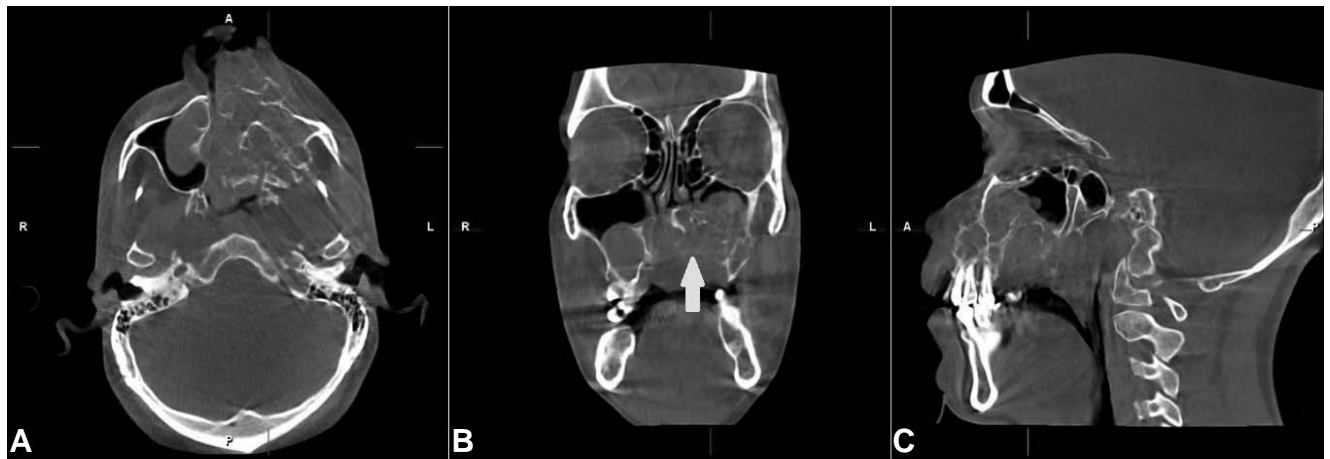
A – CBCT axial section showing multilocular lesion with crested borders extending and involving the left pterygoid plates; B – coronal section showing destruction of palate (Arrows); C – sagittal section shows undermining and infiltrative growth of multilocular lesion.
